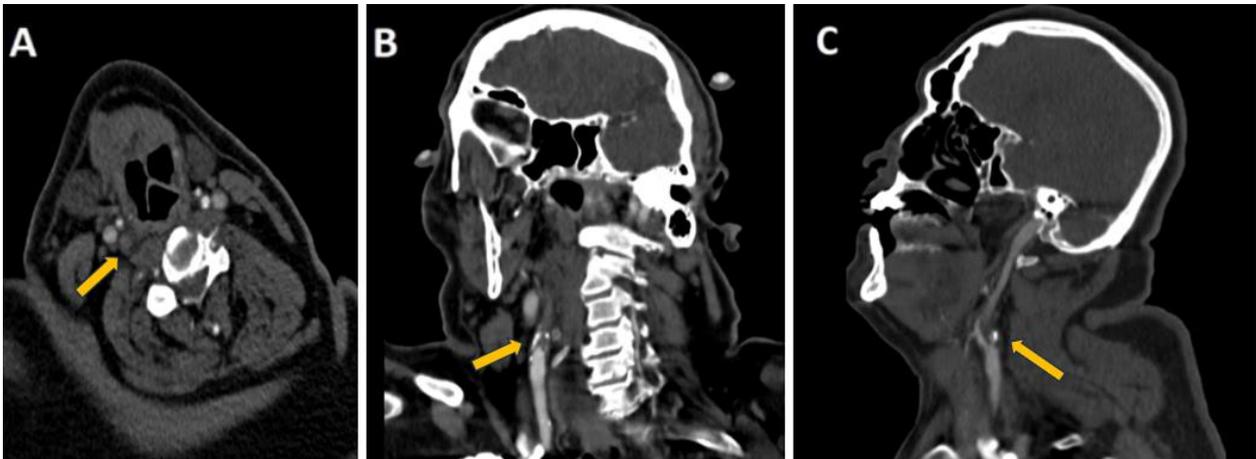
On cervical CT angiography, complete occlusion is observed in the proximal right cervical segment of ICA in A) axial section, B) coronal section, C) sagittal section.
